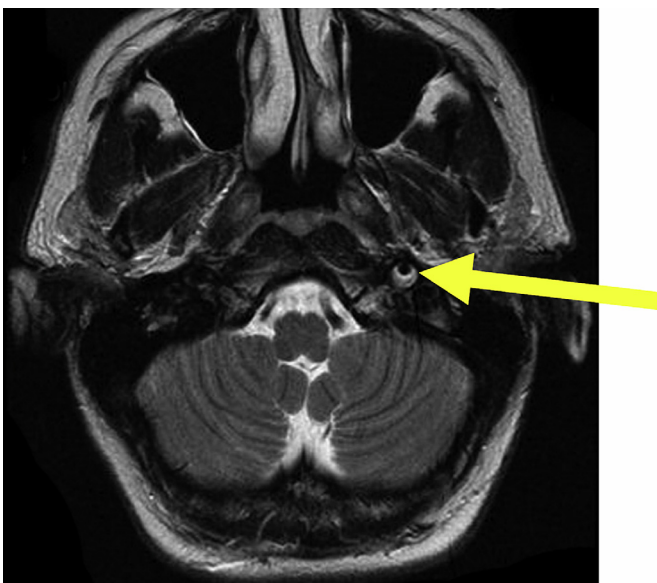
MRI with T2-weighted MRI showing blood in the arterial wall and narrowing of the lumen of the left internal carotid artery (yellow arrow), known as the "crescent sign." Case courtesy of Frank Gaillard, Radiopaedia.org, rID: 6693.
